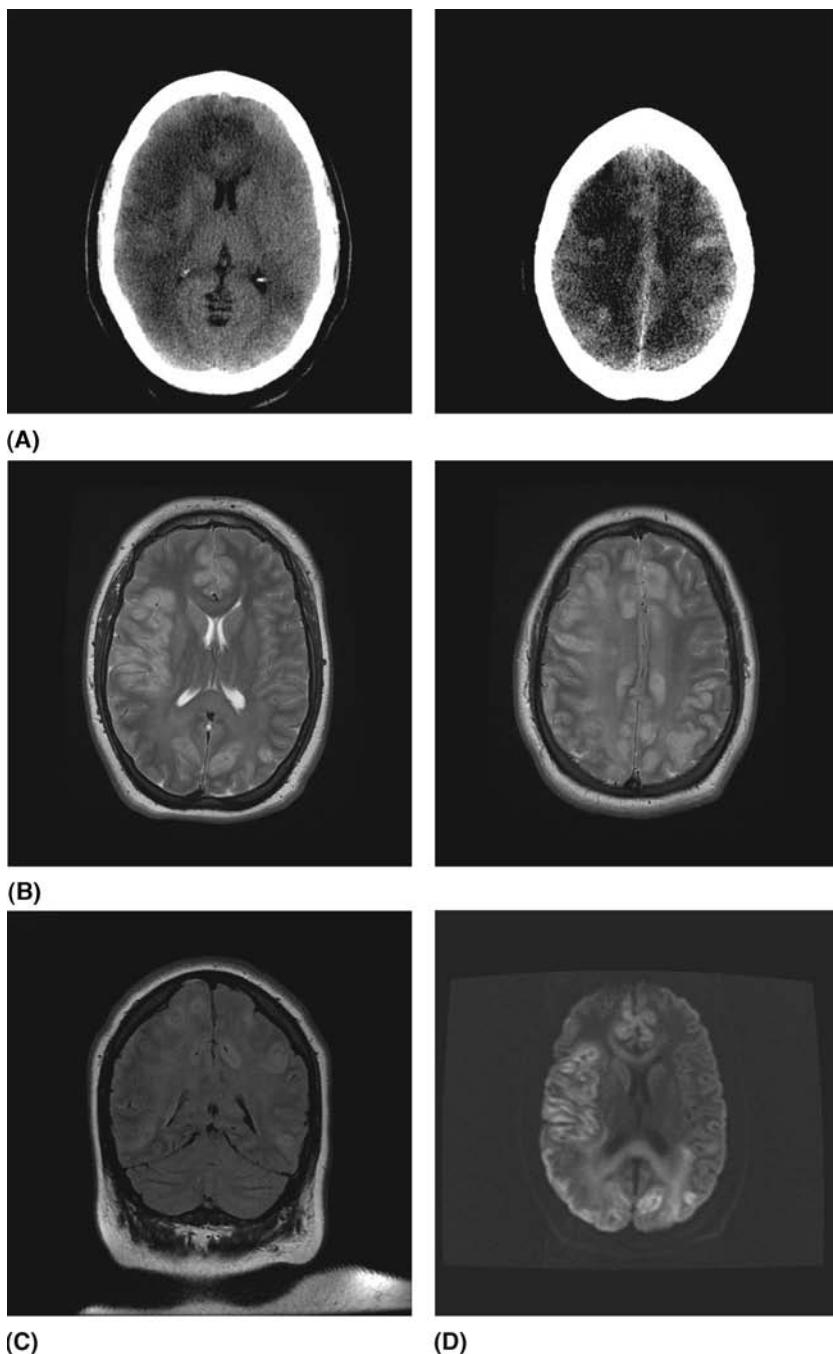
A 22-year-old pregnant woman with HELLP syndrome with a decreased Glasgow Coma Scale and dilated pupils. (A) CT brain (without contrast). Diffuse predominantly white matter low attenuation can be seen, more extensive on the right with mild mass effect. (B) Axial T2-weighted MRI. (C) Coronal FLAIR. (D) Axial diffusion. Cortical and subcortical T2 and FLAIR hyperintensity in parietal and occipital lobes and to a lesser extent the frontal lobes. Some of these lesions show restricted diffusion (low signal was seen on the corresponding ADC map). Appearances are consistent with eclampsia.
